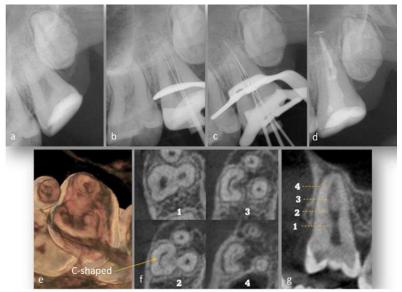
RCT of a maxillary second molar with a C-shaped canal. (a) initial radiograph, (b,c) working length determination, (d) after filling, (e) 3D reconstruction, (f) axial CBCT image from different levels (1-4) of the root canal, (g) sagittal CBCT image.
